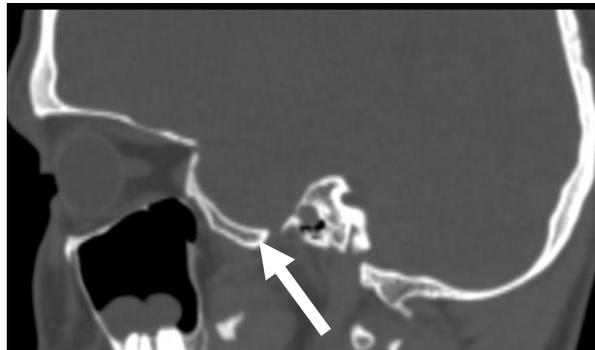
CT cisternography from 07.10.2024: bone window (sagittal view); the white arrow indicates the bony defect of the skull base
